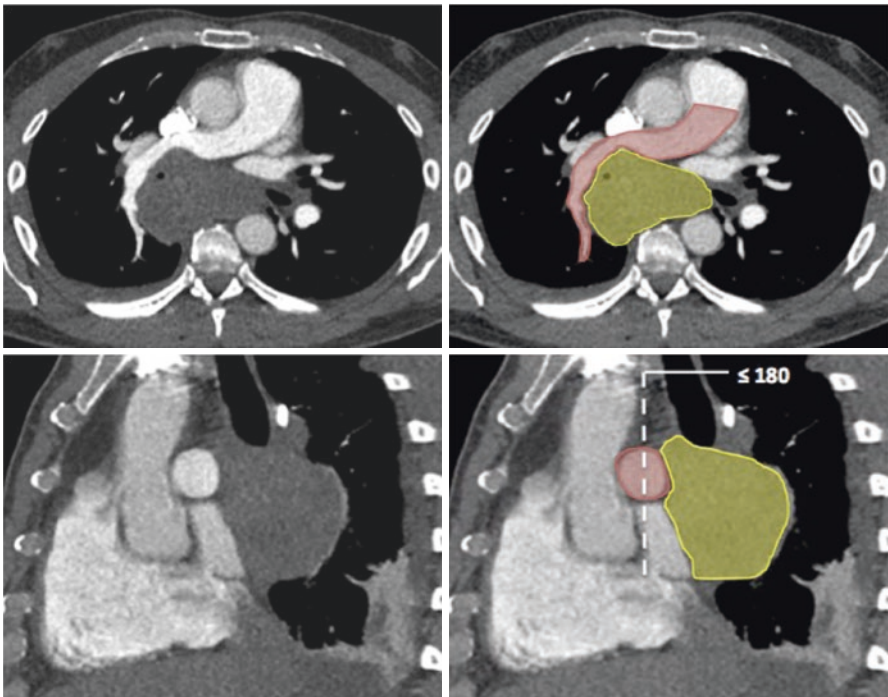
Chest CTA of a patient with non-small-cell lung cancer. Right hilar lesion with lobulated contour that presents wide contact with the main pulmonary artery, displacing it anteriorly, but without definitive signs of vascular invasion by the tumor
